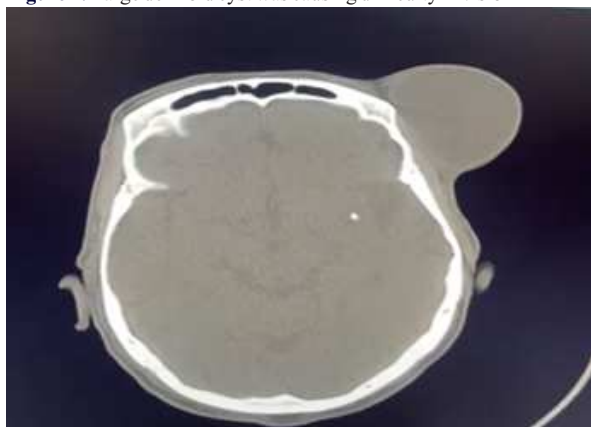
CT scan showing no bony erosion or intracranial extension
